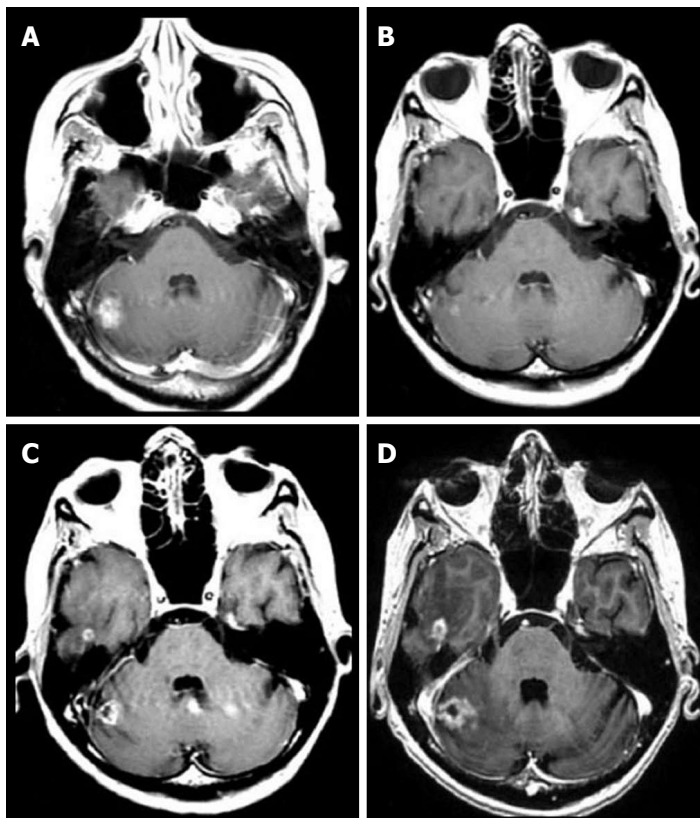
Follow-up axial enhanced T1-weighted magnetic resonance images of a lung carcinoma metastatic to the right cerebellum treated with stereotactic radiosurgery. A: Pre stereotactic radiosurgery (SRS) magnetic resonance (MR) image; B: Initial follow-up MR image at 6 wk after SRS demonstrating an initial volume reduction; C: Follow-up MR image at 9 wk demonstrating volume increase (true-progression); D: Follow-up MR image at 12 wk with final volume increase.
